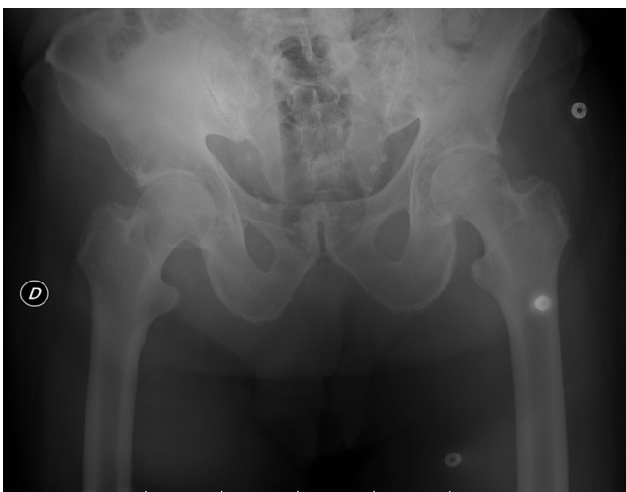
Control X-ray after reduction under general anesthesia.
